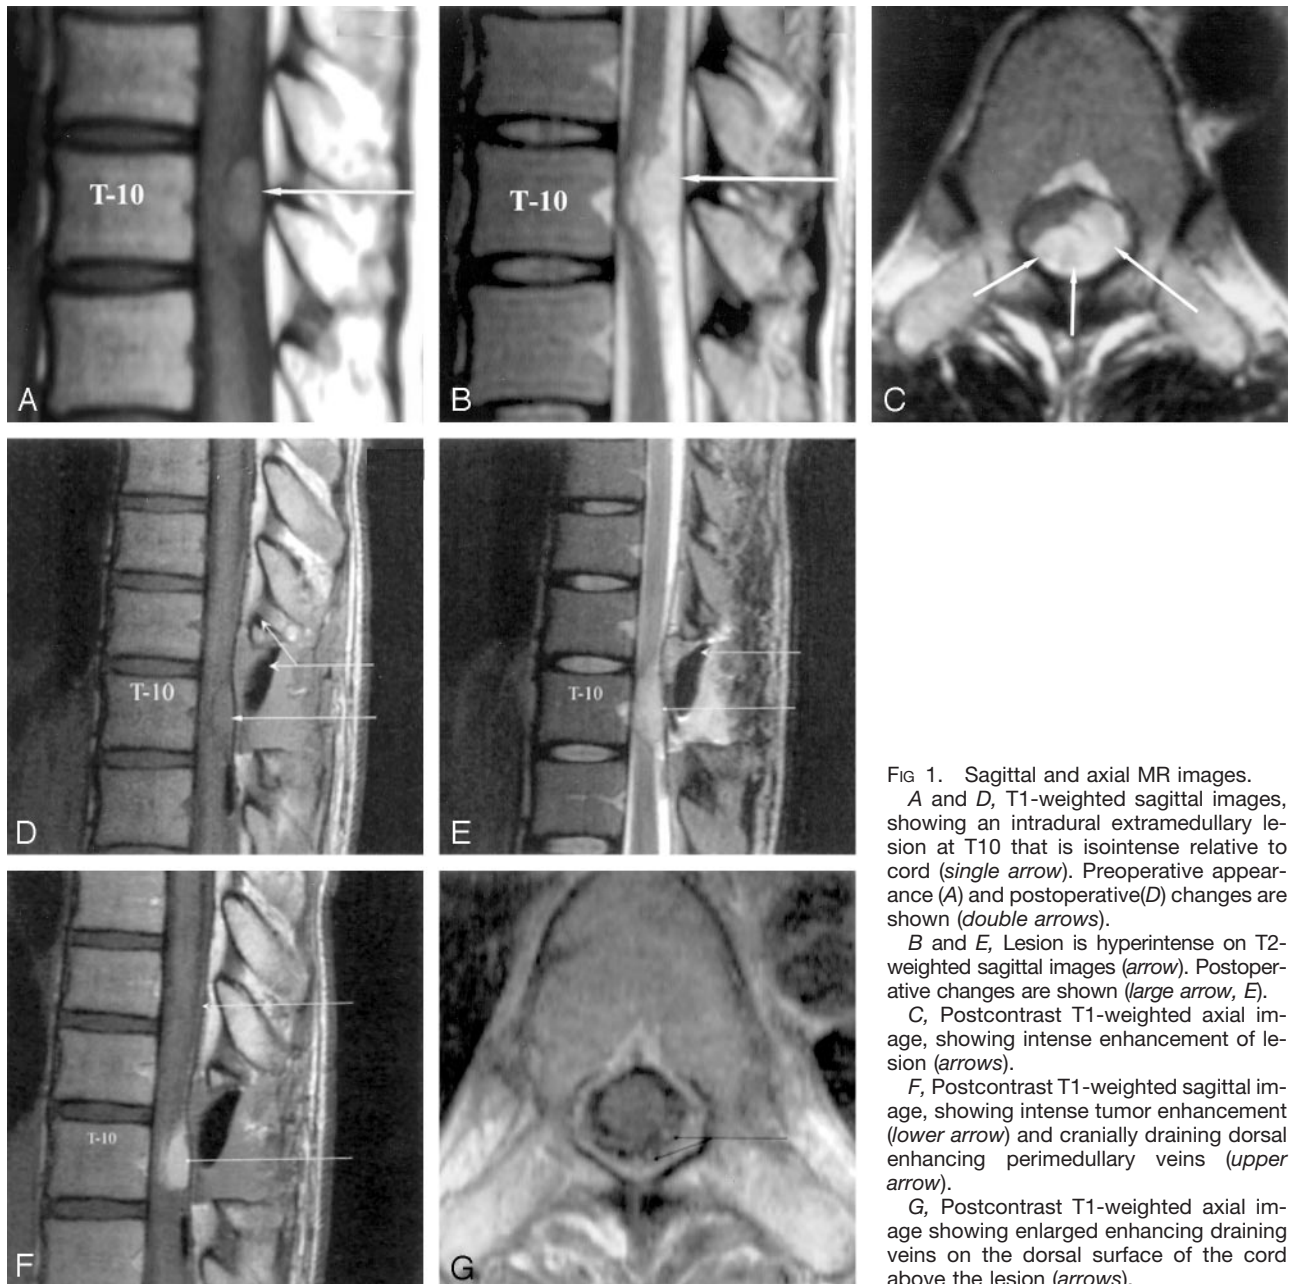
Sagittal and axial MR images.
